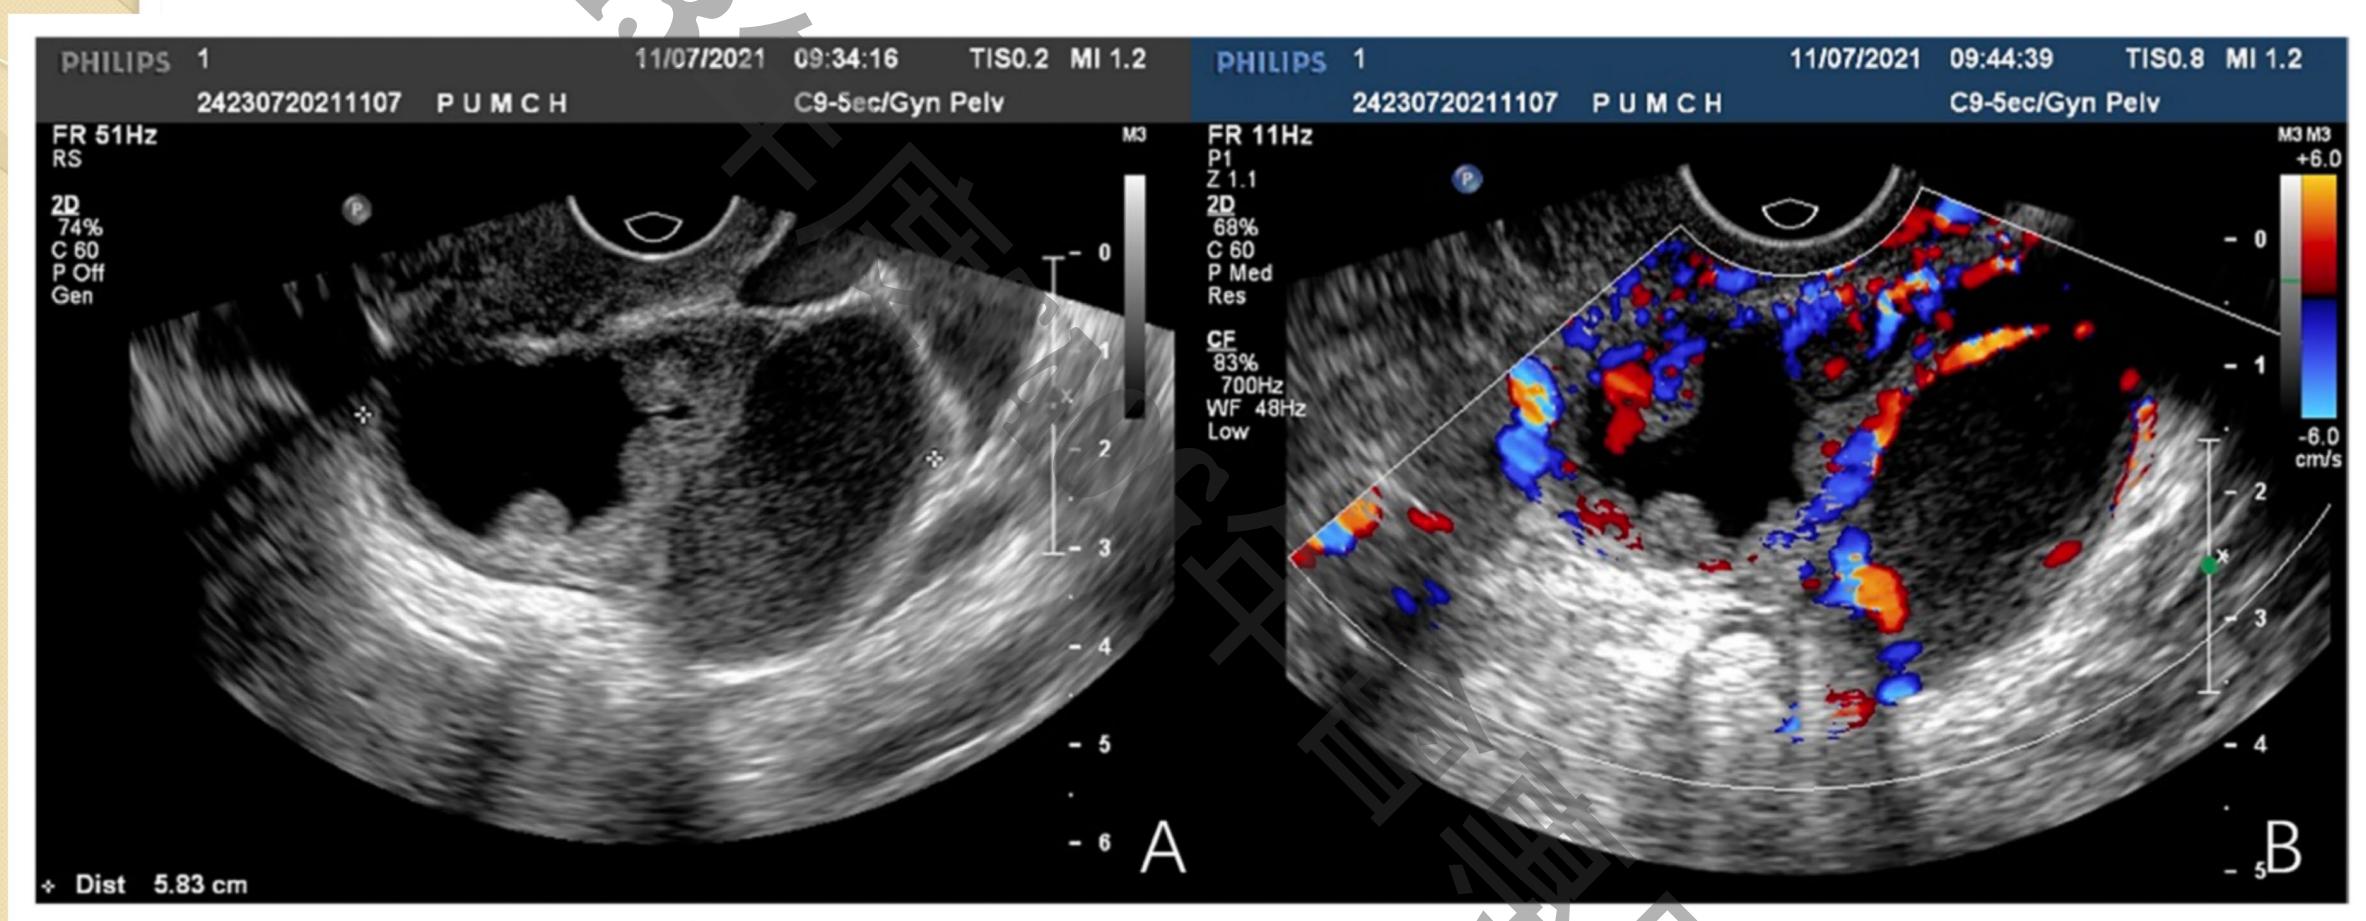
Transvaginal ultrasound imaging of the left adnexal mass. A Transvaginal ultrasound depicting multilocular cyst with thick internal walls and papillary projection protruding into the cavity. B Doppler ultrasound depicting vascularity within capsule wall and papillary projections
